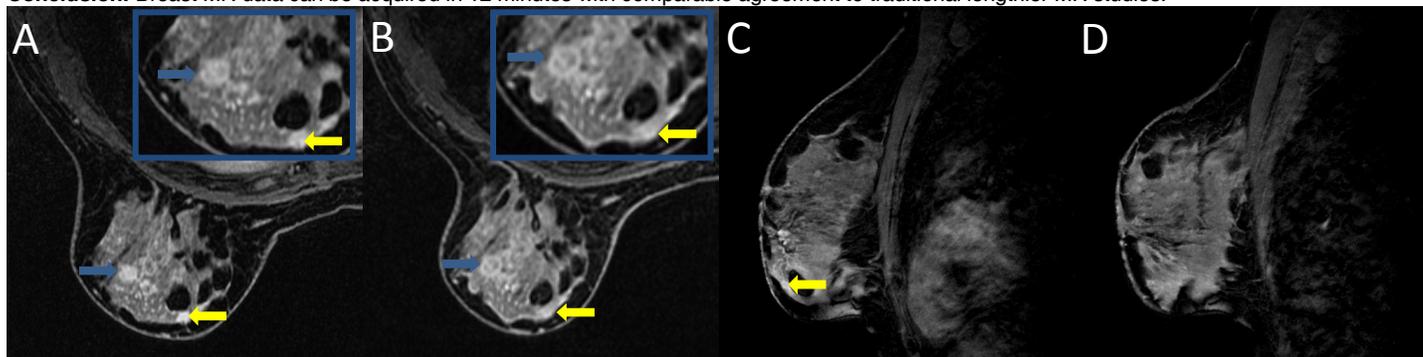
Post contrast high spatial resolution imaging from short (A), and standard breast examinations (B, C, D) demonstrating the effect timing of post contrast images has on mass enhancement and shape. Blue and yellow arrows highlight two different lesions. Note difference in mass enhancement and shape of lesions between the short and standard MR images. Lateral lesion (blue arrow) not clearly identifiable in image D.
